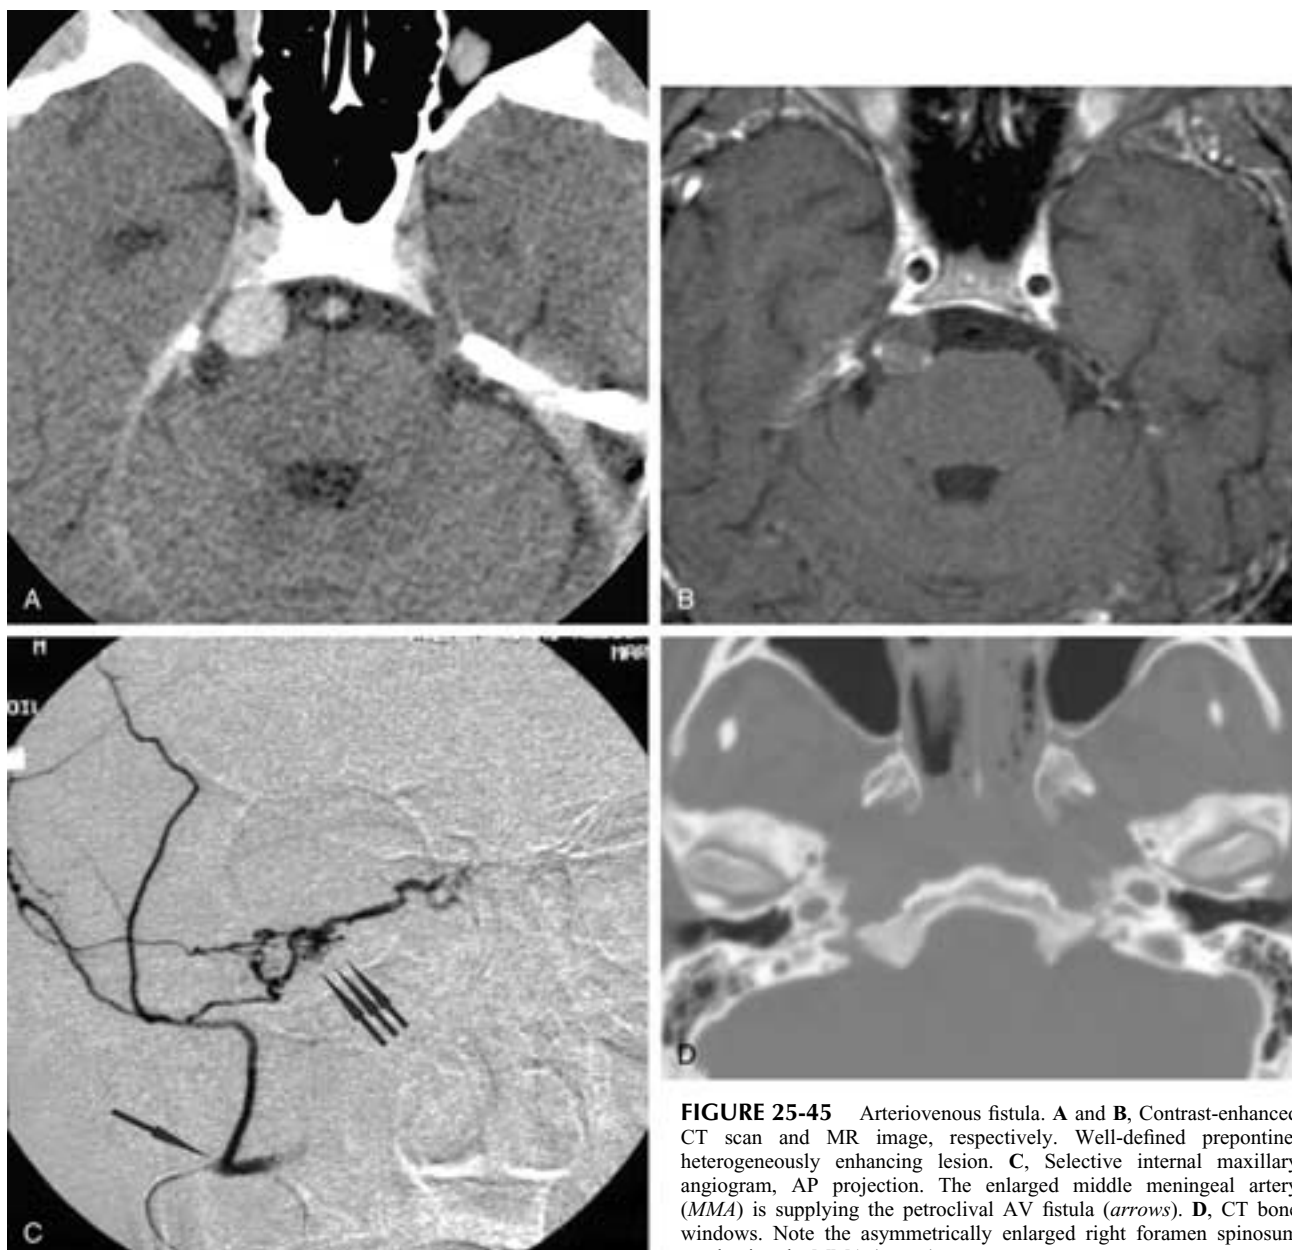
Arteriovenous fistula. A and B, Contrast-enhanced CT scan and MR image, respectively. Well-defined prepontine, heterogeneously enhancing lesion. C, Selective internal maxillary angiogram, AP projection. The enlarged middle meningeal artery (MMA) is supplying the petroclival AV fistula (arrows). D, CT bone windows. Note the asymmetrically enlarged right foramen spinosum conducting the MMA (arrow).
